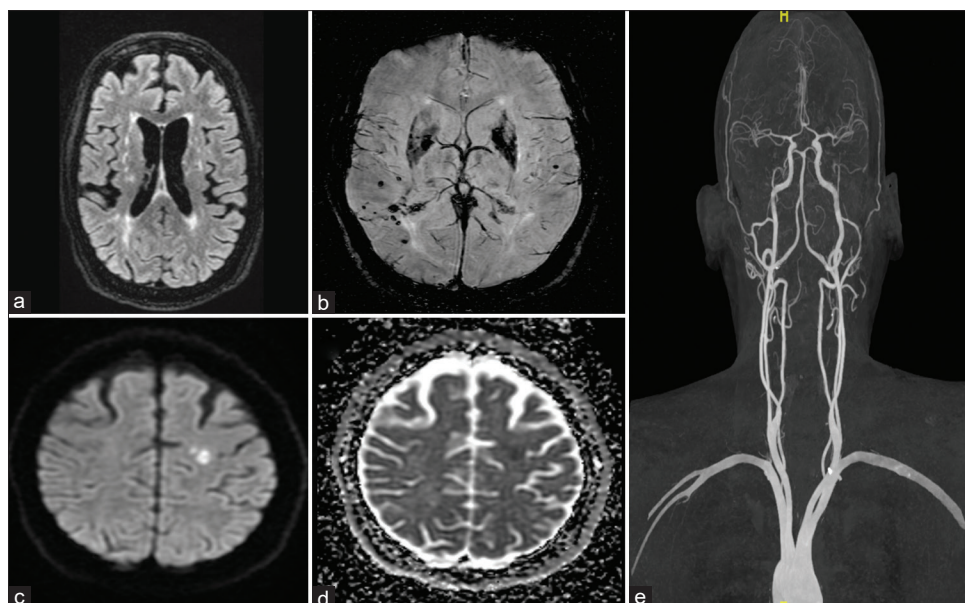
MRI brain axial FLAIR image (a) shows multiple focal and confluent white matter FLAIR hyperintensities in bilateral centrum semiovale, bilateral corona radiata, frontal and parietal white matter. Axial SWI image (b) shows multiple foci of blooming in both cortical and subcortical locations. DWI and corresponding ADC map (c, d) show focal area of diffusion restriction is seen in left centrum semiovale s/o acute lacunar infarct. (e) Contrast enhanced MR angiography showing normal head and neck and intracranial vasculature. FLAIR: Fluid attenuated inversion recovery, SWI: Susceptibility weighted imaging, DWI: Diffusion weighted imaging, ADC: Apparent Diffusion Coefficient
